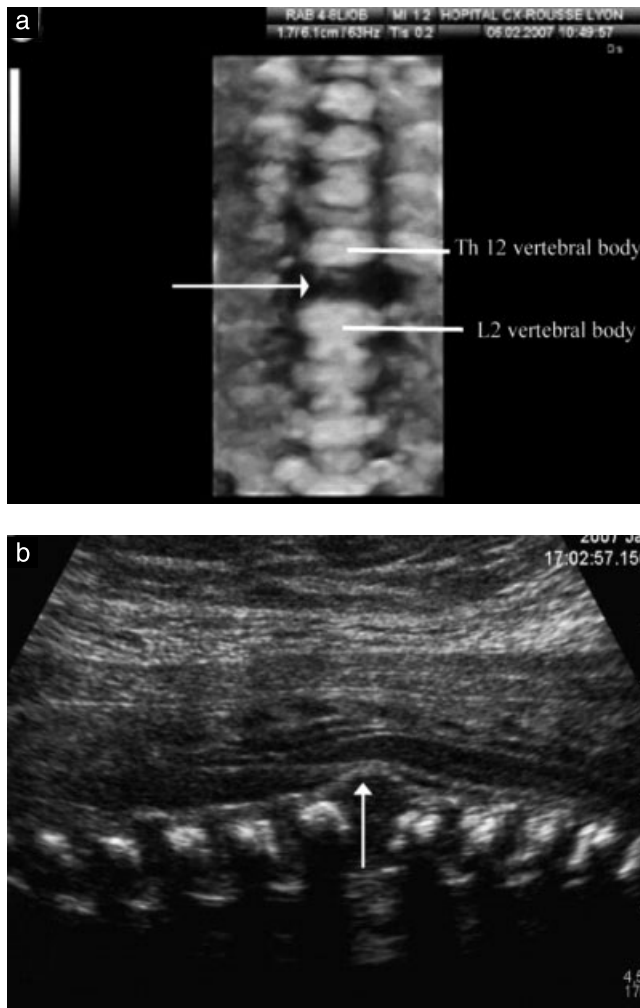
Ultrasound images of the fetal spine at 23 weeks' gestation. The three-dimensional coronal reconstruction shows the absence of vertebral body L1 (arrow) without induced scoliosis (a), while the two-dimensional sagittal section confirms the absence of the body at the L1 level and the recession of the posterior longitudinal ligaments with respect to the dura mater (arrow) (b).
